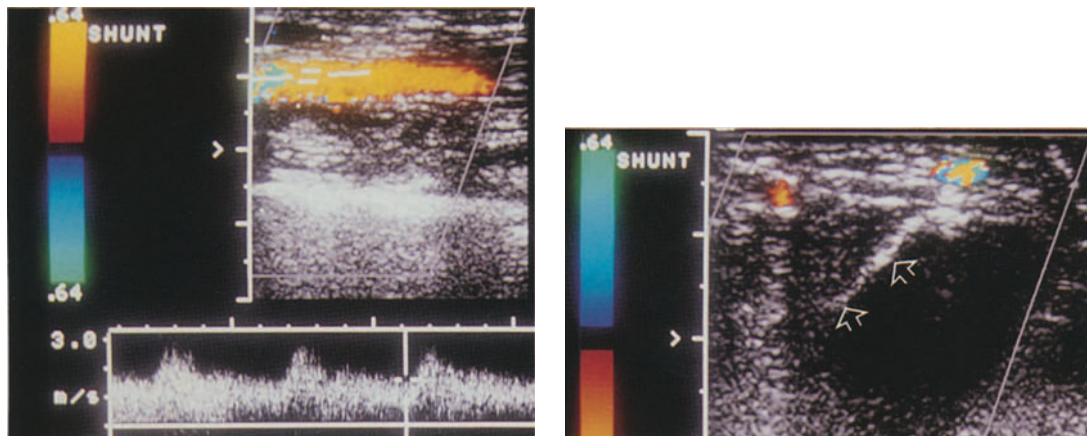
(left) Normal arterial limb of a dialysis fistula: CCDS shows color in the vessel lumen during systole and diastole with no reversed component of blood flow during diastole. The spectral waveform is typical of an A-V communication, with high diastolic blood flow velocity due to low peripheral resistance. Slight broadening of the Doppler spectrum indicates some turbulence (this finding may or may not be present in a normal fistula)
